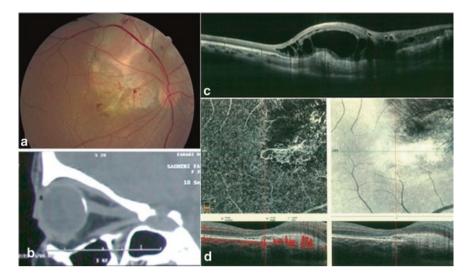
Choroidal osteoma with neovascularization. a Color fundus photography show an orange-red color lesion with mottling. b CT scan has been performed for this 50 YO male. It revealed a plaque like highly reflective lesion in the posterior pole of the eye. c EDI-OCT shows horizontal lamellar lines, and speckled regions. The standard choroidal vasculature pattern is not visible. The cystic change over the lesion is noted. d OCT-angiography reveals a fine vascular network within or over the tumor
